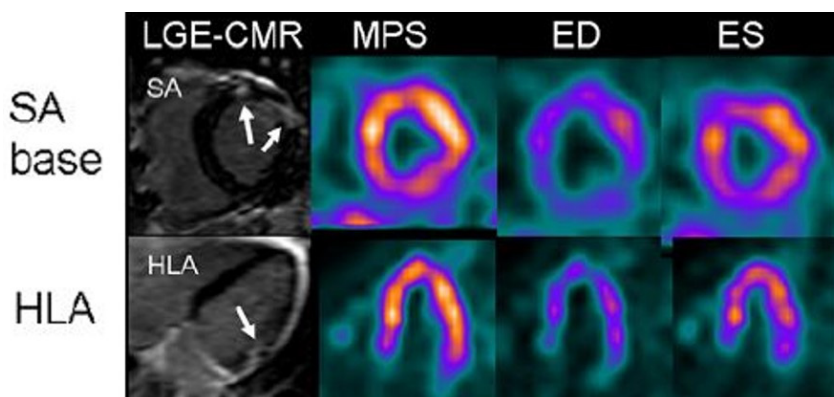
False negative myocardial perfusion SPECT (MPS). On late gadolinium enhancement cardiac magnetic resonance, anterolateral contrast enhancement is seen (arrows) not detected by MPS.
